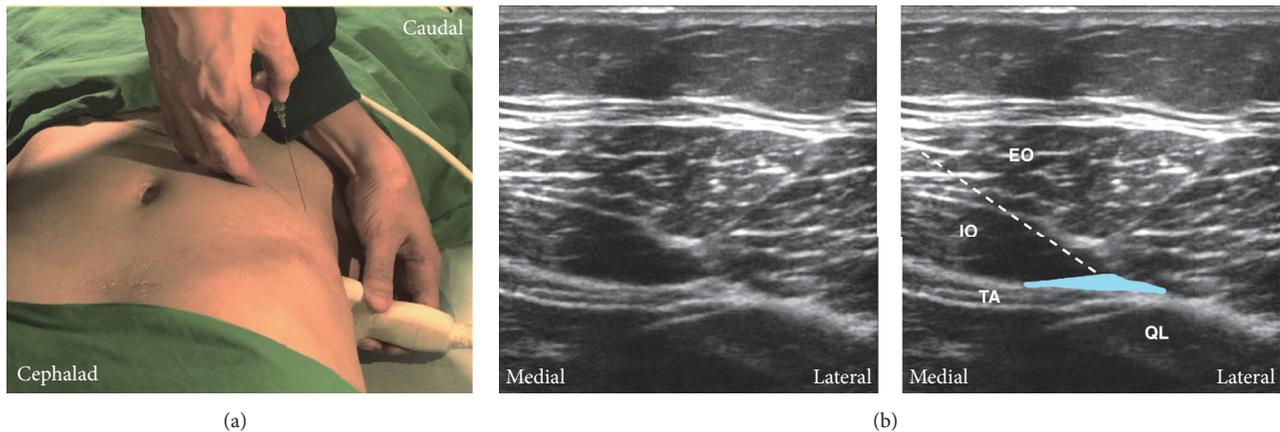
Posterior approach of transversus abdominis plane (TAP) block. (a) The probe position and needle trajectory. The probe is placed posterior to the midaxillary line between the costal margin and the iliac crest. The needle is inserted in plane. (b) Corresponding ultrasound images. Posteriorly, transversus abdominis tails off and turns into the aponeurosis. The quadratus lumborum can be seen posteromedial to the aponeurosis. The injection site is at the TAP between internal oblique and transversus abdominis posterior to the midaxillary line and near the aponeurosis. White dashed line: needle trajectory. Light blue area: the deposition site of local anesthetic. TA: transversus abdominis; IO: internal oblique; EO: external oblique; QL: quadratus lumborum.
